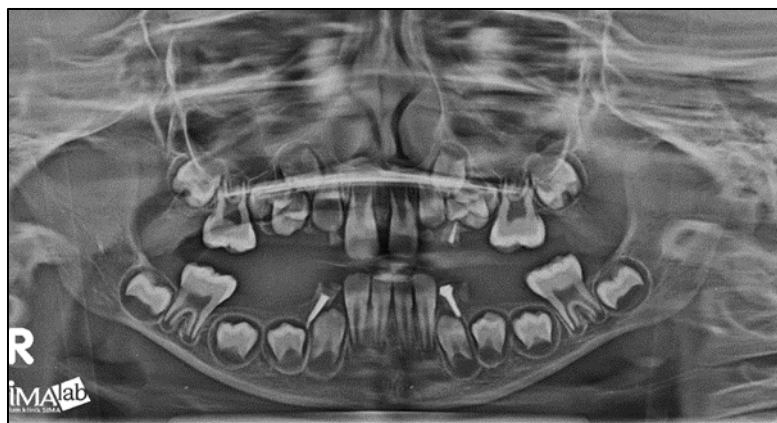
Radiograph Examination
